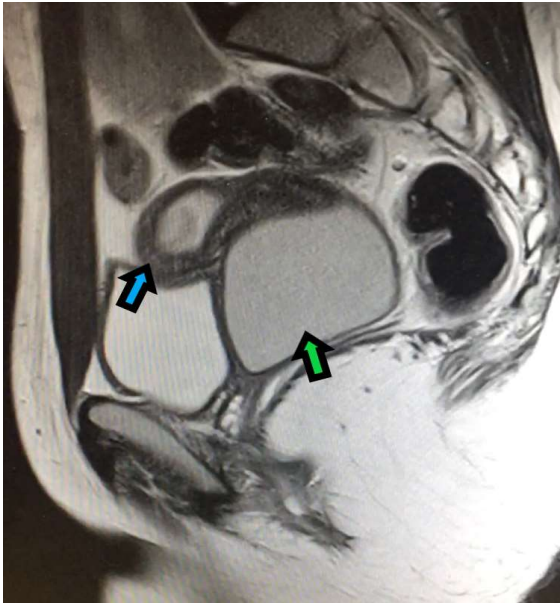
MR image showing 50 x 55 mm fluid accumulation in the left half of the vagina which was compatible with hematocolpos starting from 3.5 cm proximal to the vaginal introitus.
